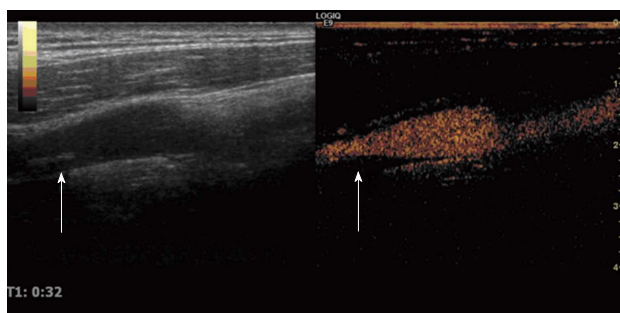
Presence of the vasa vasorum in carotid artery plaque. There are mild ultrasound contrast agents in carotid artery plaque (arrow).
